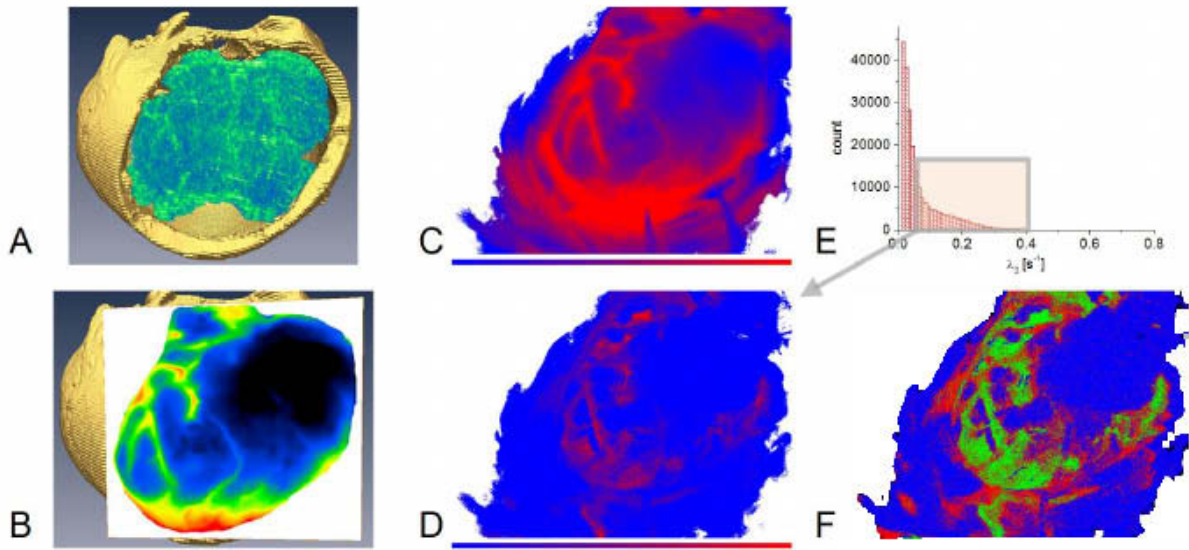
This figure shows the results of case 5. In A, the infarct demarcation is segmented as green-blue in a post-operative CT recording. Subimage B shows the orientation of the thermal image to the CT dataset. C depicts the temperature distribution at equilibrium temperature after the irrigation. D displays the spatial distribution of λ_2 and E shows the histogram of all λ_2 values. F represents the segmentation as result of fitting the 3-Gaussian mixture model. Blue represents the ischemic / low perfusion state, green the healthy state and red representing uncertainty. The estimated underperfused tissue state strongly correlates with post-operative infarct demarcation. Some tissue is located near well perfused arteries (green) and might indicate areas that might be affected by further ischemic progression. Compared to the raw temperature image of B the results allow inferring more detailed information regarding the tissue perfusion.
